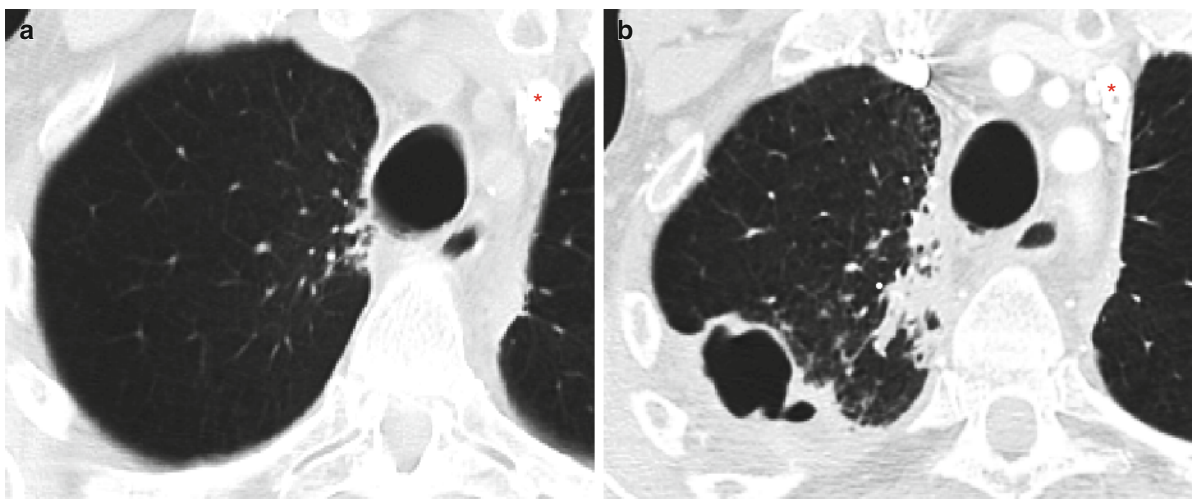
(a) Subtle paramediastinal pneumonitis and calcified lymph nodes (*) after RT for Hodgkin's lymphoma. (b) Follow-up CT after 12 months shows increased pneumonitis and pulmonary necrosis in the apex of the right lung. No associated infection was identified
